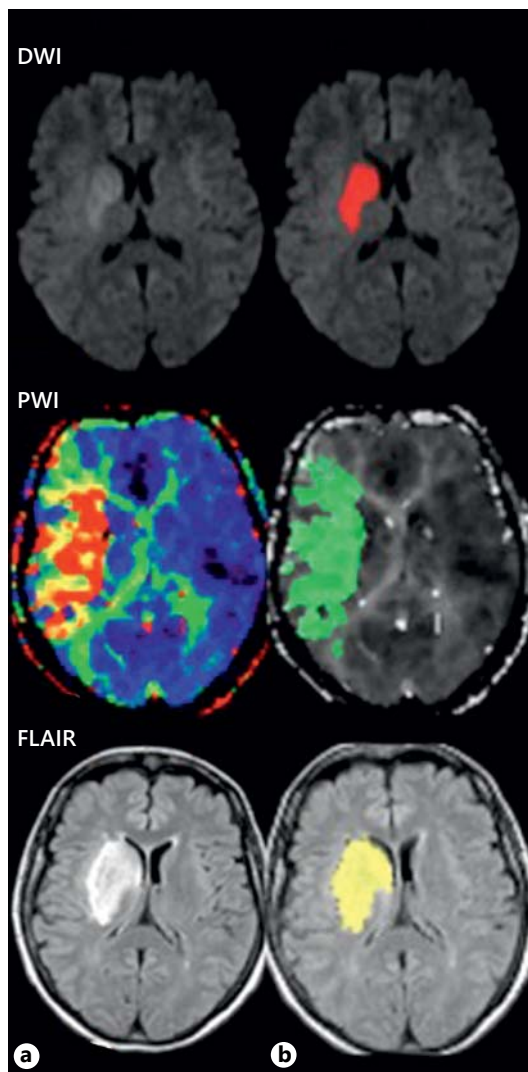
Example of lesion masks after co-registration to the initial ADC map. a Lesion masks were outlined on the initial DWI, PWI (T_{\max} map, threshold 4 s) and 1-month follow-up FLAIR. b Next, all images (T_{\max} map and FLAIR) and corresponding lesion masks were co-registered to the initial DWI (ADC map). Note the lower in-plane spatial resolution of the FLAIR images after co-registration.
